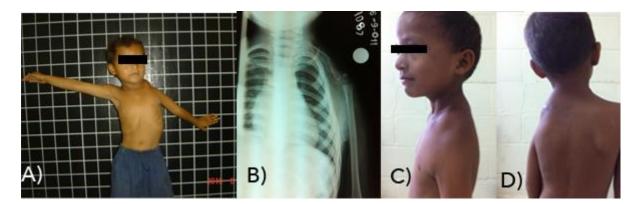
A) Six months post surgery, the child had regained functional range of motion with 800 of abduction B)Looked cosmetically better but C) Left shoulder contour remained flattened D) Radiograph at six months showing regeneration of the left scapula in the periosteal sleeve.
